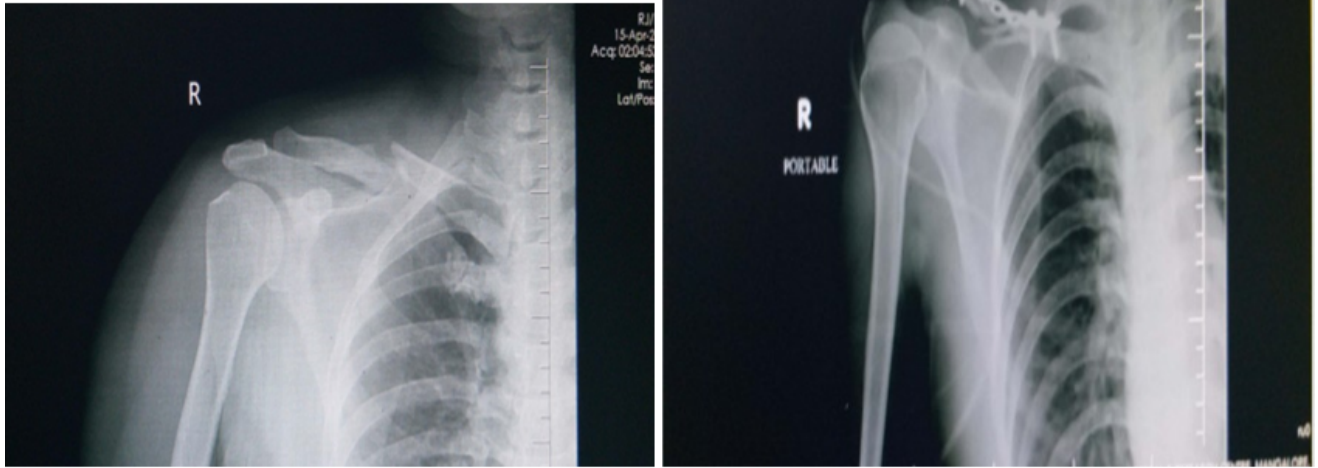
X-ray of an operated patient
